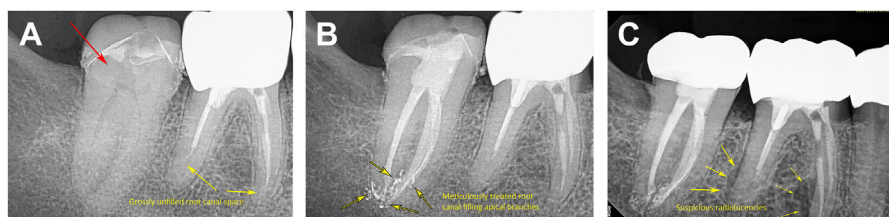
(A) Preoperative radiograph before root canal treatment (RCT) of a mandibular second molar (red arrow). Also note the inadequately treated first molar with unfilled root canal space. (B) Immediate post-treatment radiograph showing complete filling of the root canal space without voids and treatment of all exiting branches at the root apex. (C) A 3.5-year post-treatment radiograph showing unremarkable healing of the treated second M and periradicular radiolucencies consistent with recurrent endodontic disease associated with the first molar.
